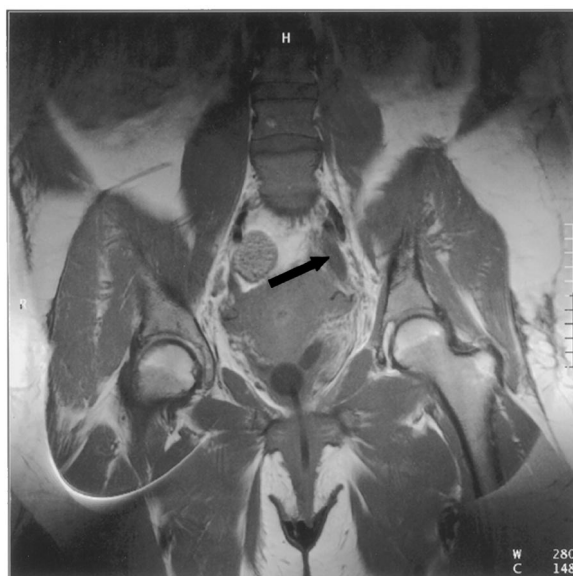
Magnetic resonance imaging: precontrast T-1 weighted image of the pelvis showing a tubular structure with decreased signal representing clot in left ovarian vein (arrow).
